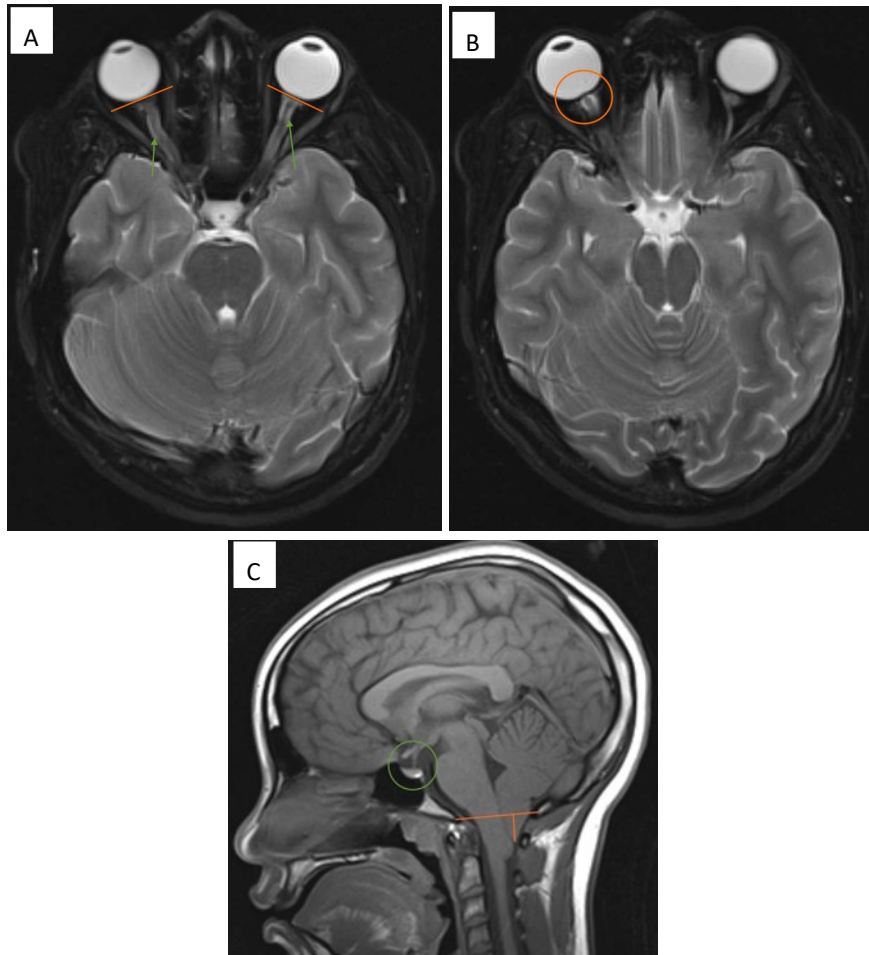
1 Initial MRI showed a peg-like 1.9 cm Chiari 1.5 malformation (Image A, sagittal T1 non-contrasted image, orange markings); partially empty sella (Image A, green circle); bulging of the perioptic nerve sheath (Image B, axial T2 with fat suppression, green arrows); and flattening of the posterior sclera (Image B, orange markings) with bulging of the optic disc (Image C, axial T2 with fat suppression, orange circle) were seen; these findings, in conjunction with grade V papilledema on fundoscopy led to a diagnosis of severe intracranial hypertension (IH).
